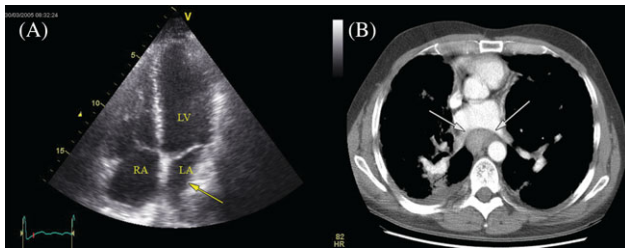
Transthoracic echocardiography (A) shows an impression of the left atrium (arrow) due to lymphadenopathy in sarcoidosis, in a haemodynamically stable patient with progressive dyspnoea and reduced exercise tolerance. LA, left atrium; RA, right atrium; LV, left ventricle. Colour flow Doppler echocardiography (not included) demonstrated turbulent flow from the pulmonary veins into the left atrium, indicating compression of the pulmonary veins. The additional CT scan (B) revealed a mediastinal mass posterior to the left atrium (arrows).
